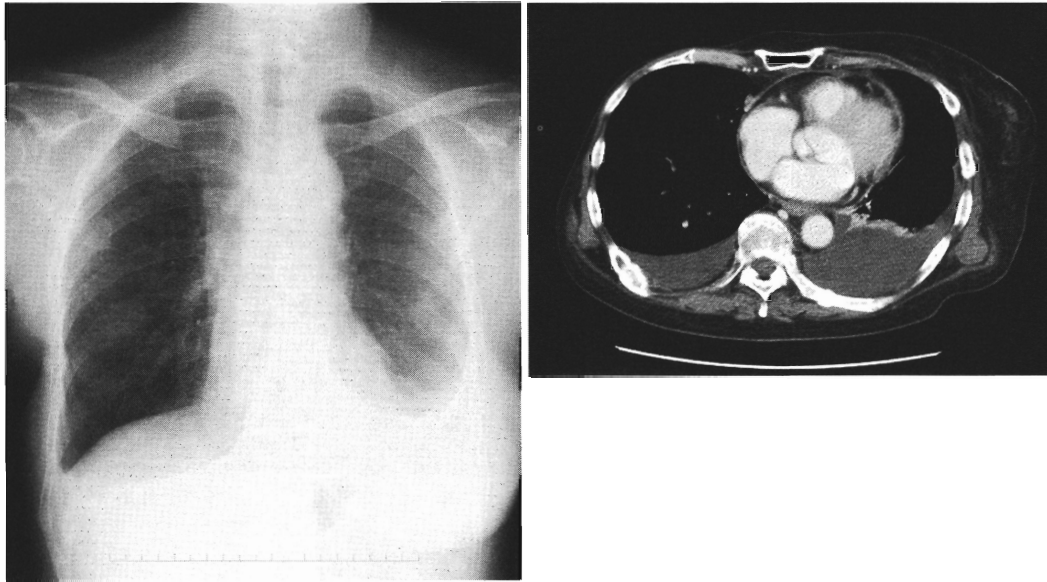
Chest radiography and chest CT
